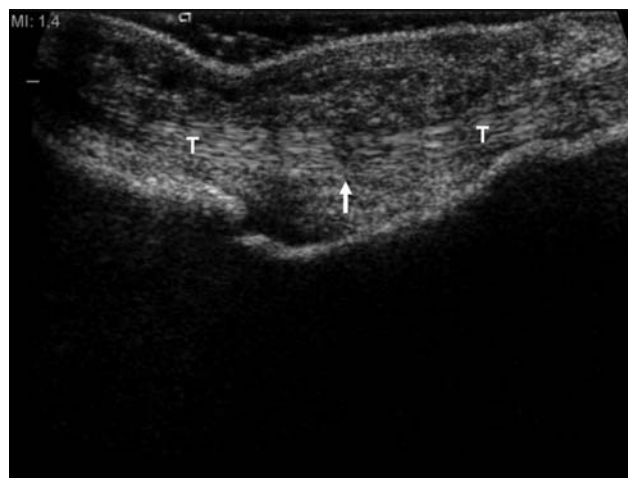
Repaired-intact tendon, fibrillar continuity, and normal thickness of tendon are seen in ultrasonography. No gap or fibrotic tissue is seen at rupture site. Arrow shows repair site. T: Tendon.
